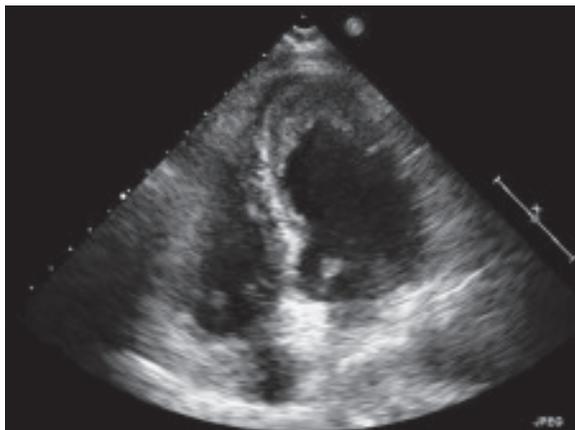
Representative trans-thoracic echocardiogram image of pure variant of apical hypertrophic cardiomyopathy
